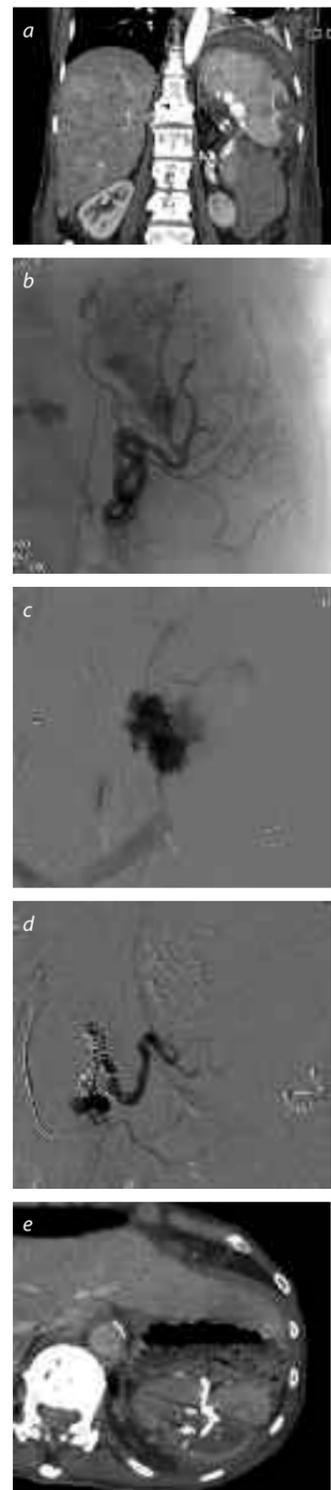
69-year-old patient referred in unstable haemodynamic condition after an attempt of percutaneous drainage of a perisplenic collection after colectomy. (a) Coronal CT reformation showing active bleeding in the splenic hilum and peri-splenic hematoma after. (b) Splenic angiogram shows massive bleeding in the liver hilum as well as multiple bleeding sites in the upper pole of the spleen. (c) Selective catheterisation of the ruptured branch shows active bleeding and is subsequently embolised using glue. (d) Angiogram after proximal splenic artery embolisation using coils. One month later the spleen has regenerated, please note the glue in the ruptured artery from the hilum.
